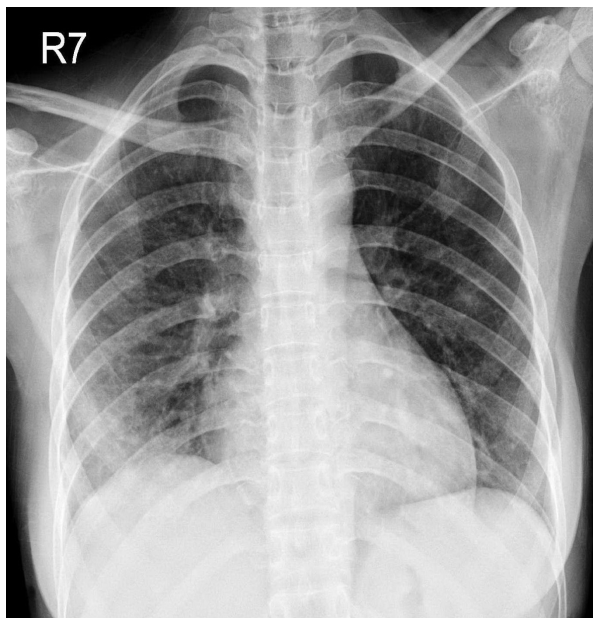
Initial chest radiograph on PTD 19 revealed an unremarkable lung lesion.
